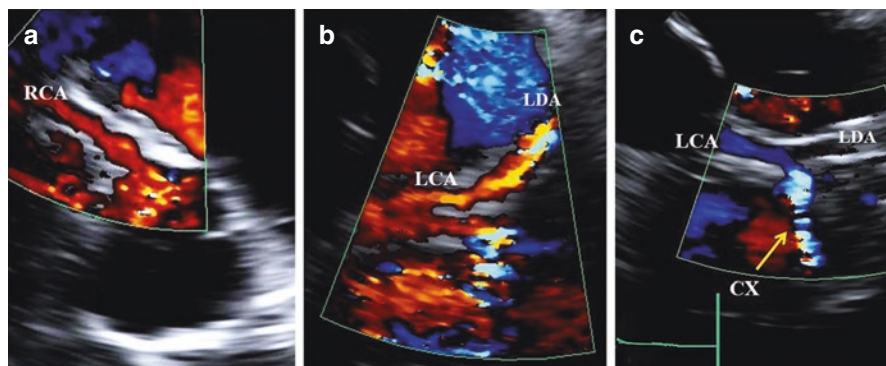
Echocardiographic 2D visualization of (a) the right coronary artery (RCA), (b) left coronary artery (LCA), (c) circumflex artery (CX). Images were obtained by the parasternal short-axis view of the aorta using a low-scale color-Doppler imaging. LAD left anterior descending artery
